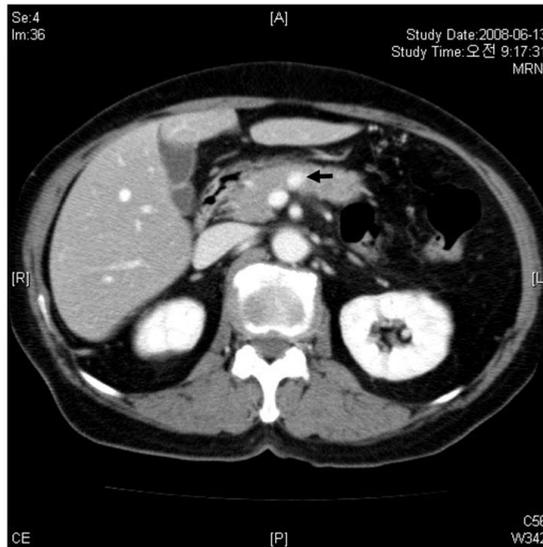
Abdominal CT scan. About 1.5cm sized hypervascular mass was noted near the neck of the pancreas (arrow)
